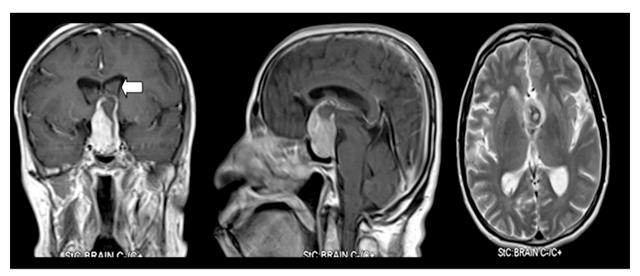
Magnetic resonance imaging (MRI) of the brain demonstrates a large sellar and suprasellar mass with an iso-intense signal with homogenous enhancement, apart from an area of acute intraventricular hemorrhage, which is also seen on the floor of the frontal horn of the lateral ventricle (white arrow) and down to the 4th ventricle.
